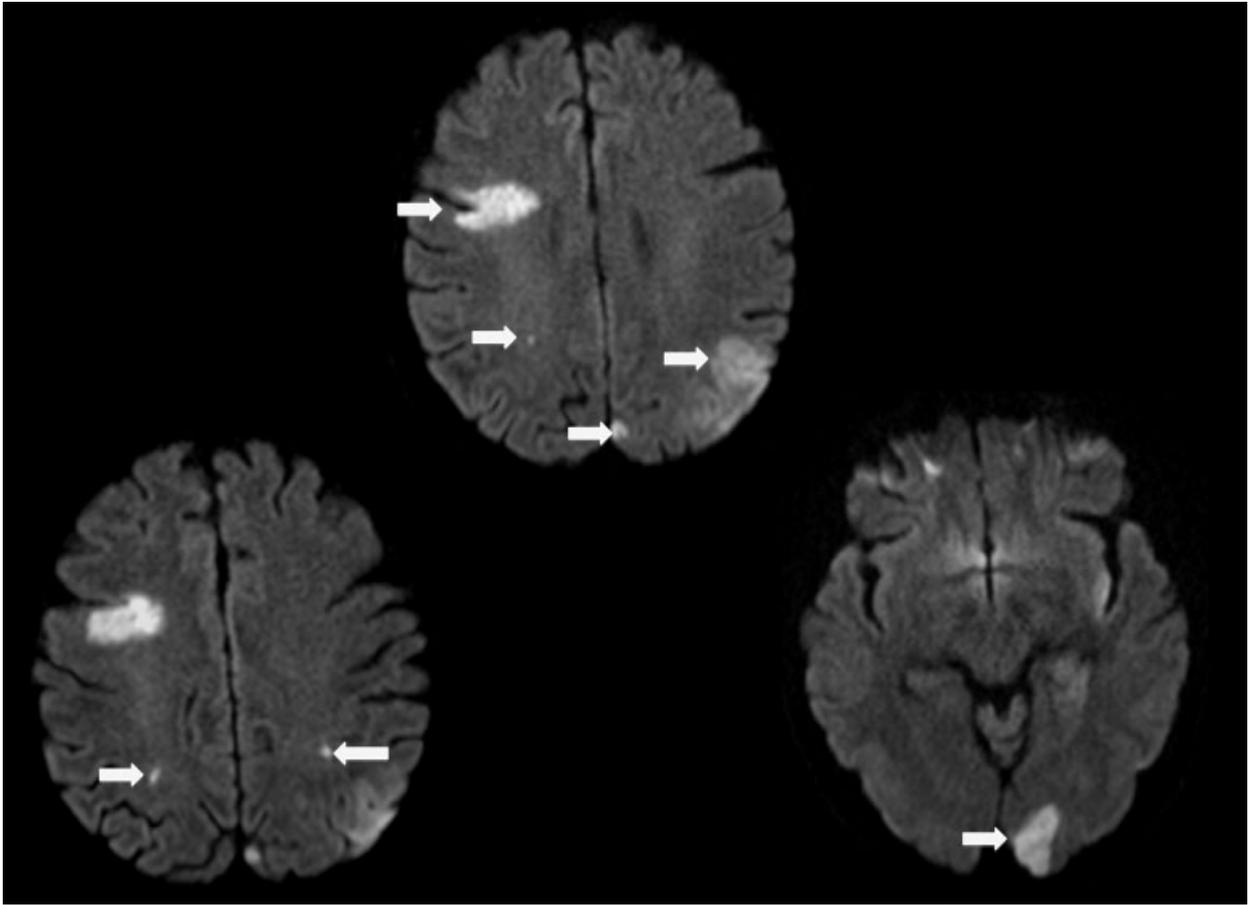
This is patient in the intensive care unit with acute change in mental status without clear focal motor neurological defects. The person was found to have a field cut, neglect, and mild aphasia. In this figure, three slices of a diffusion weighted magnetic resonance image (MRI) scan are shown. The bright lesions (white arrows) represent acute strokes. The diffuse distribution of the strokes suggests an embolic shower as the cause of the alteration of mental status.
